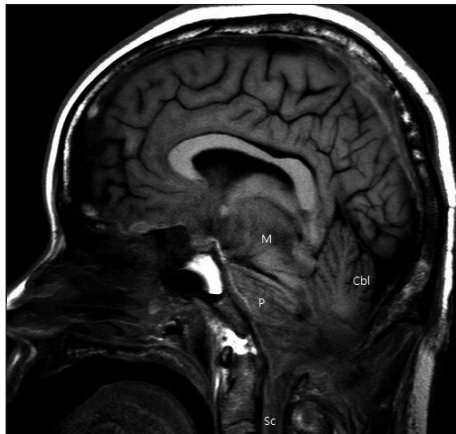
Brain magnetic resonance imaging, after 27 days of admission, shows swelling of the brain stem and cerebellum combined with trans-tentorial and foraminal herniation. There are also signal changes on the lower part of the pons and cerebellum, and pontomedullary continuity is not observed. M : midbrain, P : pons, Cbl : cerebellum, Sc : spinal cord.
